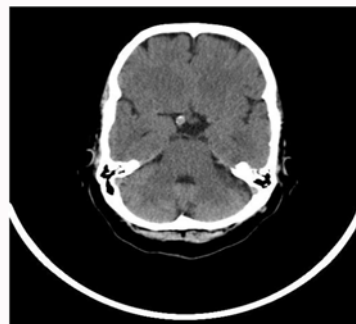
Brain computed tomography without contrast.
